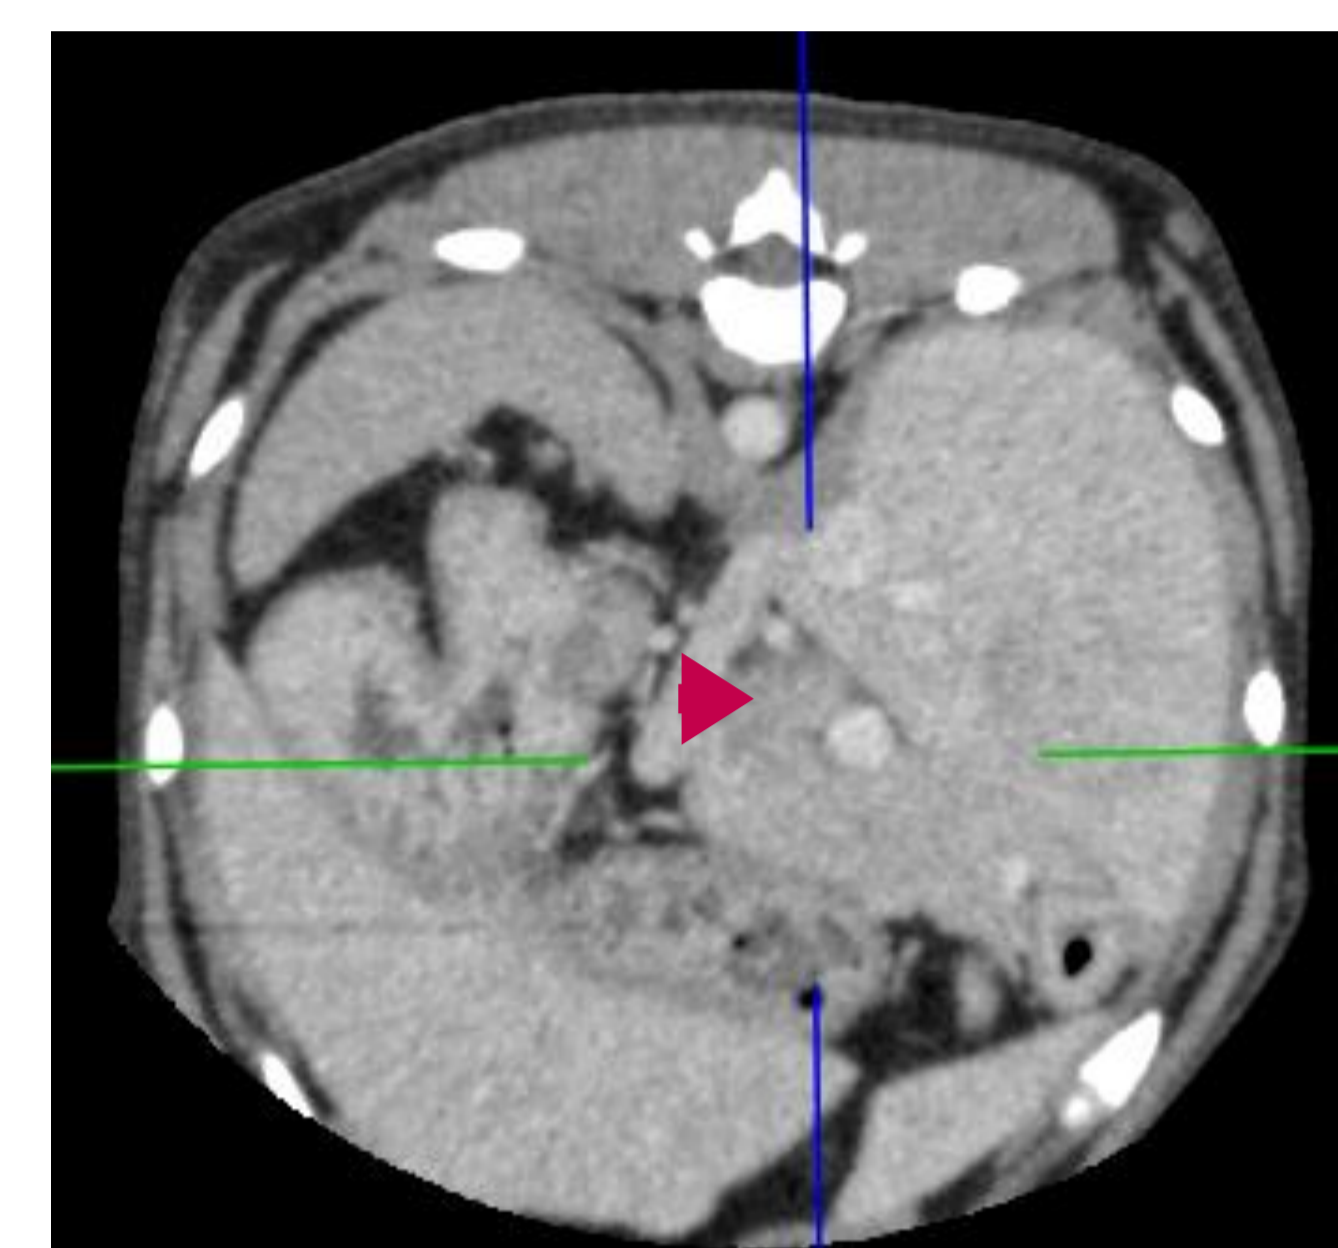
CT image showing marked enlargement of the hepatic lymph nodes measuring up to 17mm diameter
